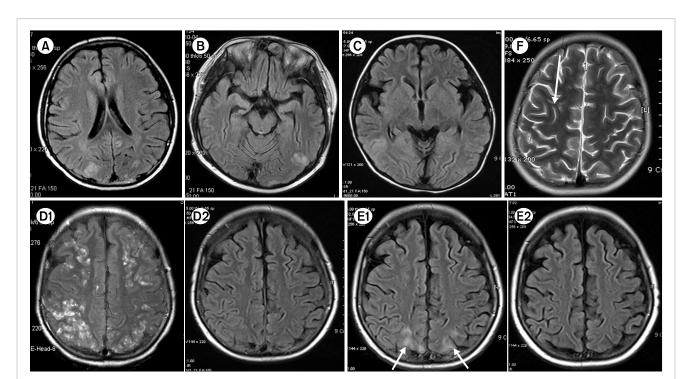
Magnetic resonance images (MRI) in patients with posterior reversible encephalopathy during treatment with the HLH-2004 protocol. MRI showed decreased signal on T1-weighted images and hyperintense abnormalities on T2-weighted and fluid attenuated inversion recovery (FLAIR) images (A–F) typical for PRES, bilaterally in the subcortical white matter and cortical gray matter of the posterior parietal and occipital lobes. These initial increased signal lesions completely disappeared after 1 to 2 months of treatment (D2 and E2).
